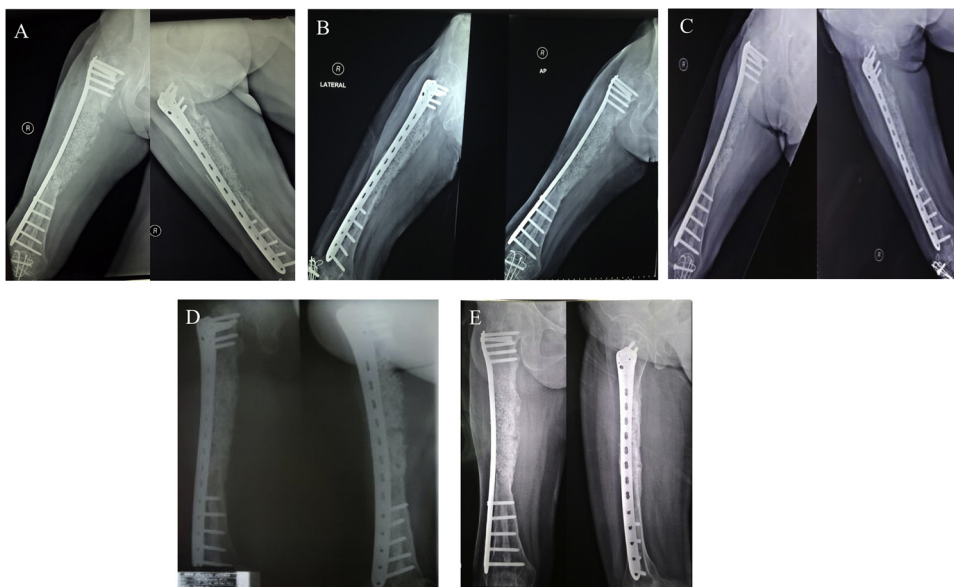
Post-Operative follow up AP and Lateral Femur X-Rays; A: 1 month; B: 3 months; C: 6 months; D: 9 months; E: 12 months.
